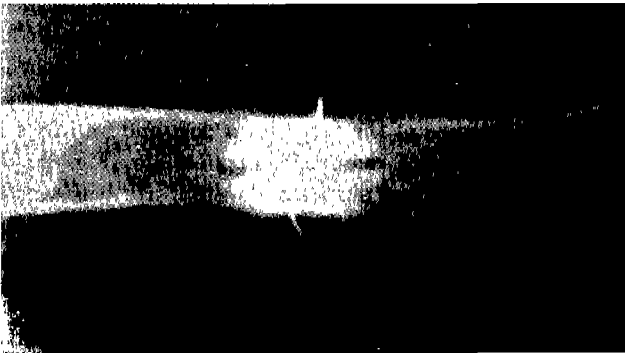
Radiograph after removing the bone plate. 8/14/91.
